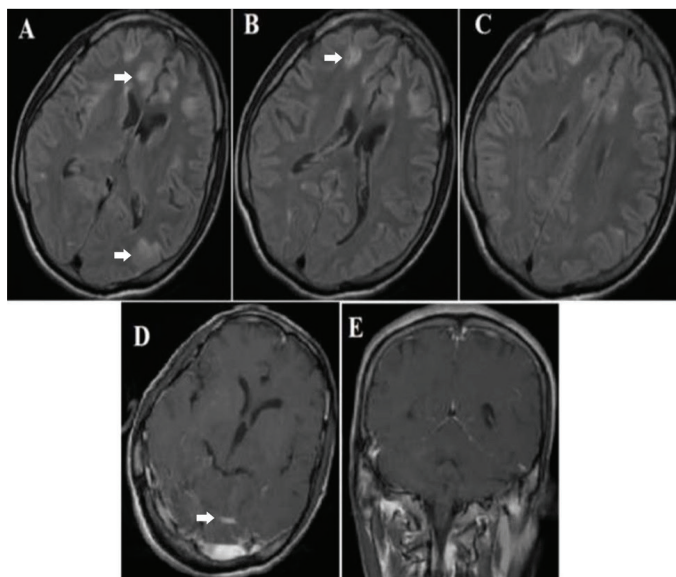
A, B, C) Bilateral hyperintense lesions involving the frontal, temporal and parieto-occipital lobes on the axial T2 weighted and FLAIR images. D, E) Bilateral patchy contrast enhancement involving the frontal, temporal and parieto-occipital lobes and leptomeningeal contrast enhancement on axial and coronal T1 weighted images
